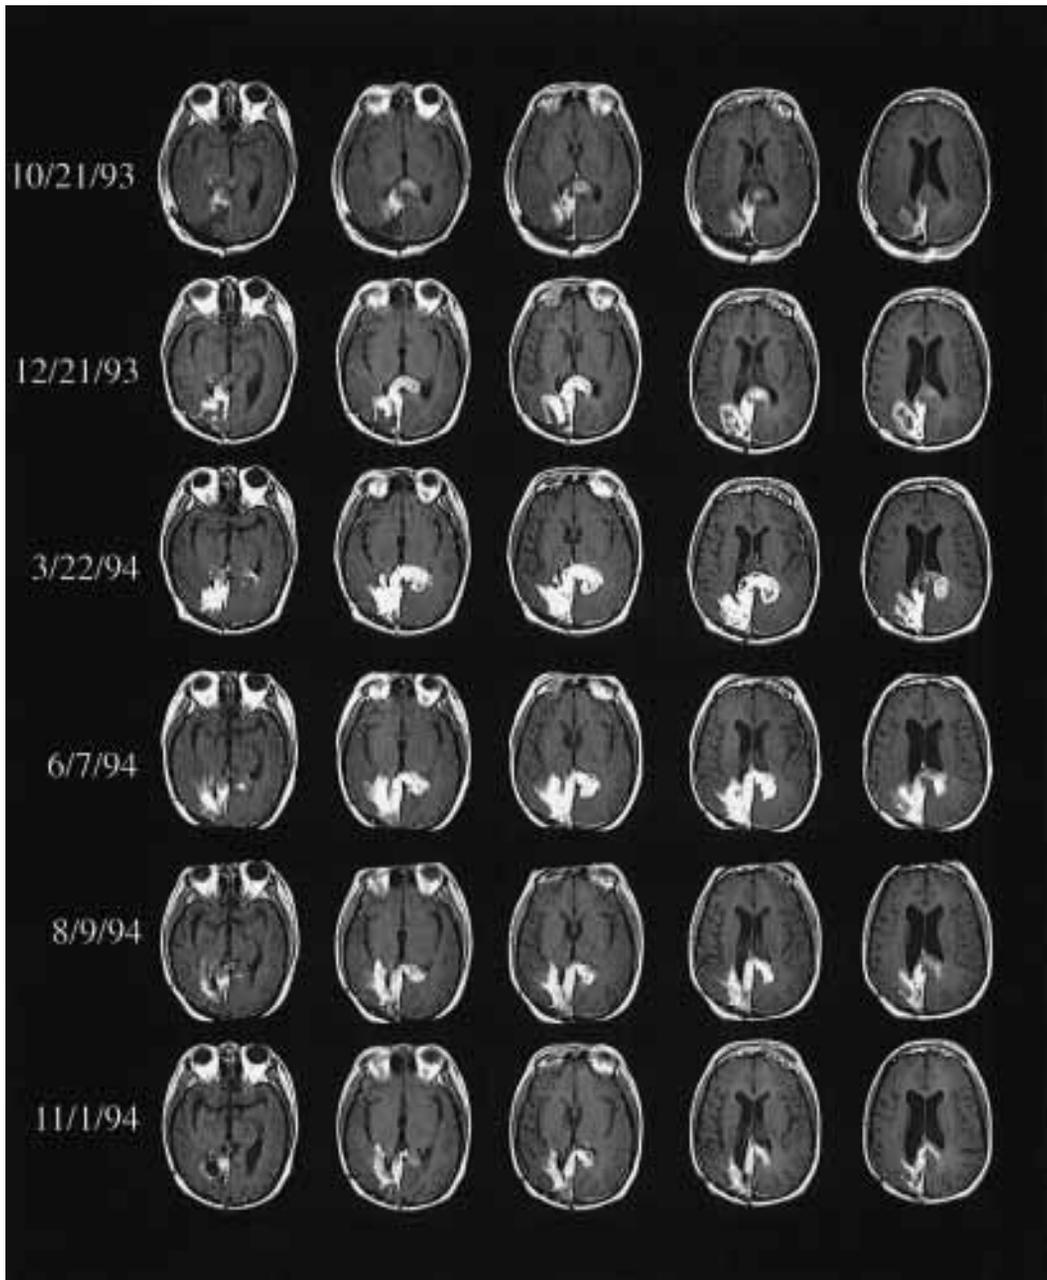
Registration of MRIs obtained at different dates showing progression of contrast enhancing portion of tumor followed by eventual regression. MRI registration was performed using a rapid automated algorithm for aligning and reslicing tomographic images [22].
